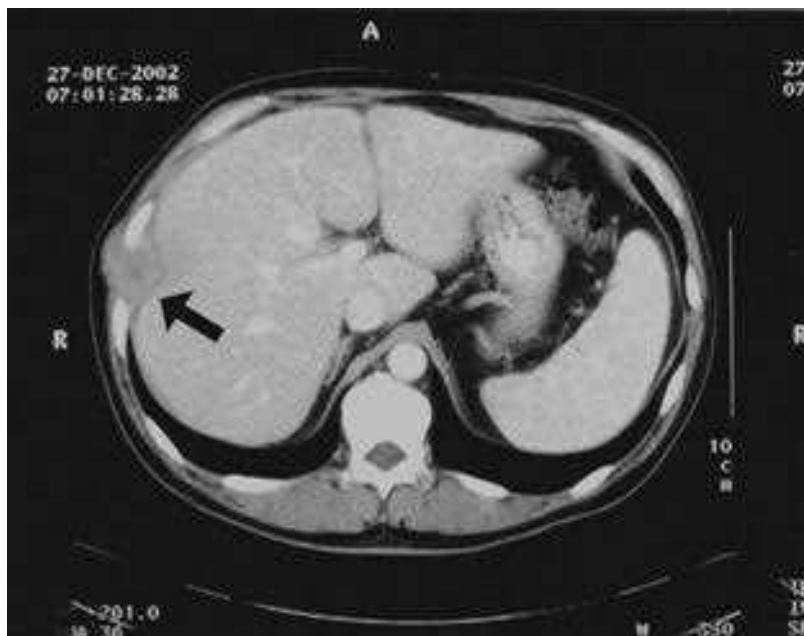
Chest computed tomography scan showing a right chest wall tumor (*arrow*). Tissue diagnosis revealed that this mass was a leiomyosarcoma.
